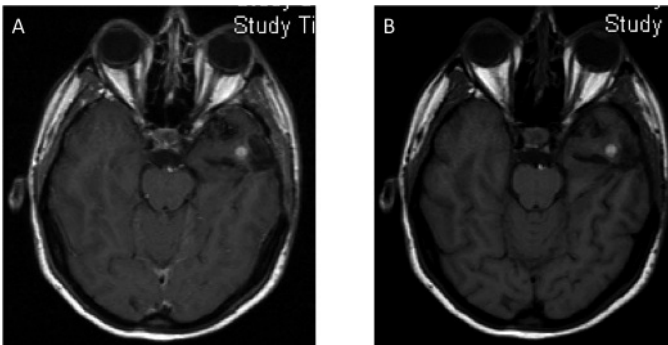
A, B) 2-year MRI. Little hyperintensity in T1 sequence, in the temporal left region.
